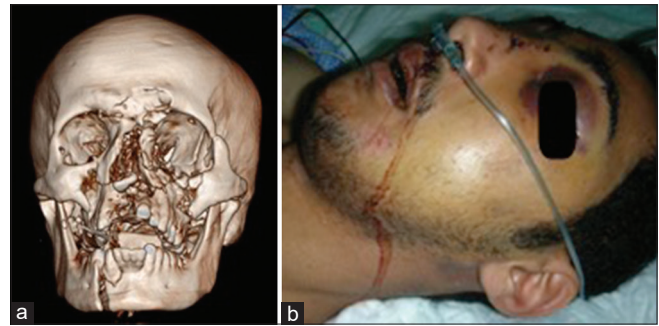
(a) Three-dimensional computed tomography scan of panfacial fracture showing severe nasoethmoidal complex disruption. (b) Patient with evidence of cerebrospinal fluid rhinorrhea in panfacial fractures
